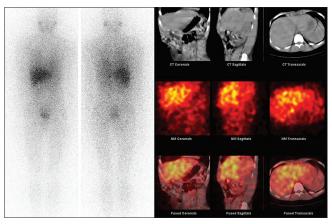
A 25-year-old male presented with hypertension for 10 years. Biochemically vesicular monoamine transporter (VMA) was borderline elevated. Computerized tomography (CT) of the abdomen was normal. Iodine-131 metaiodobenzyl guanidine (MIBG) whole body scintigraphy and single photon emission computed tomography/CT showed physiological distribution of MIBG. Patient is being clinically followed-up without evidence of neuro-endocrine tumor
